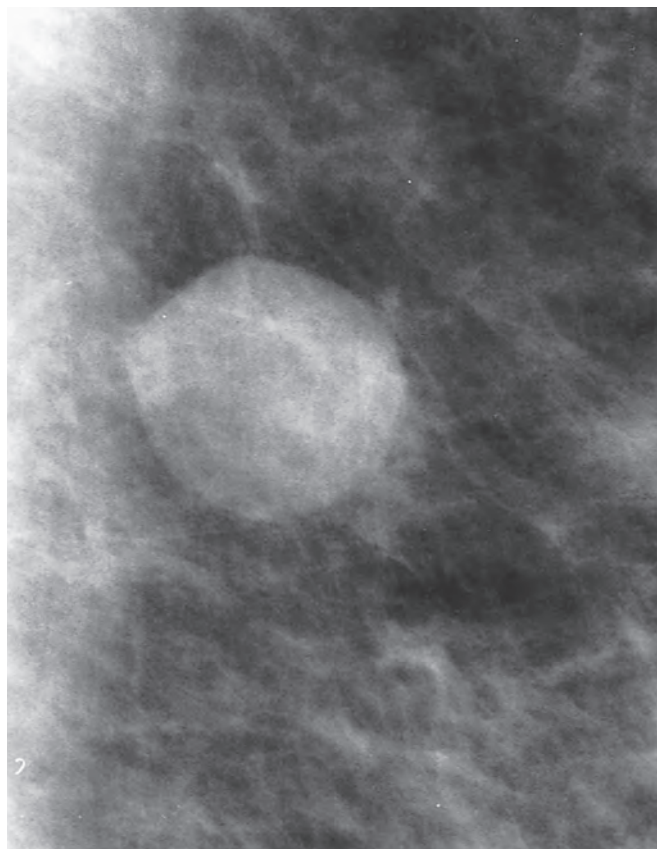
Smoothly margined round 14-mm mass. Sonogram demonstrated a simple cyst.
